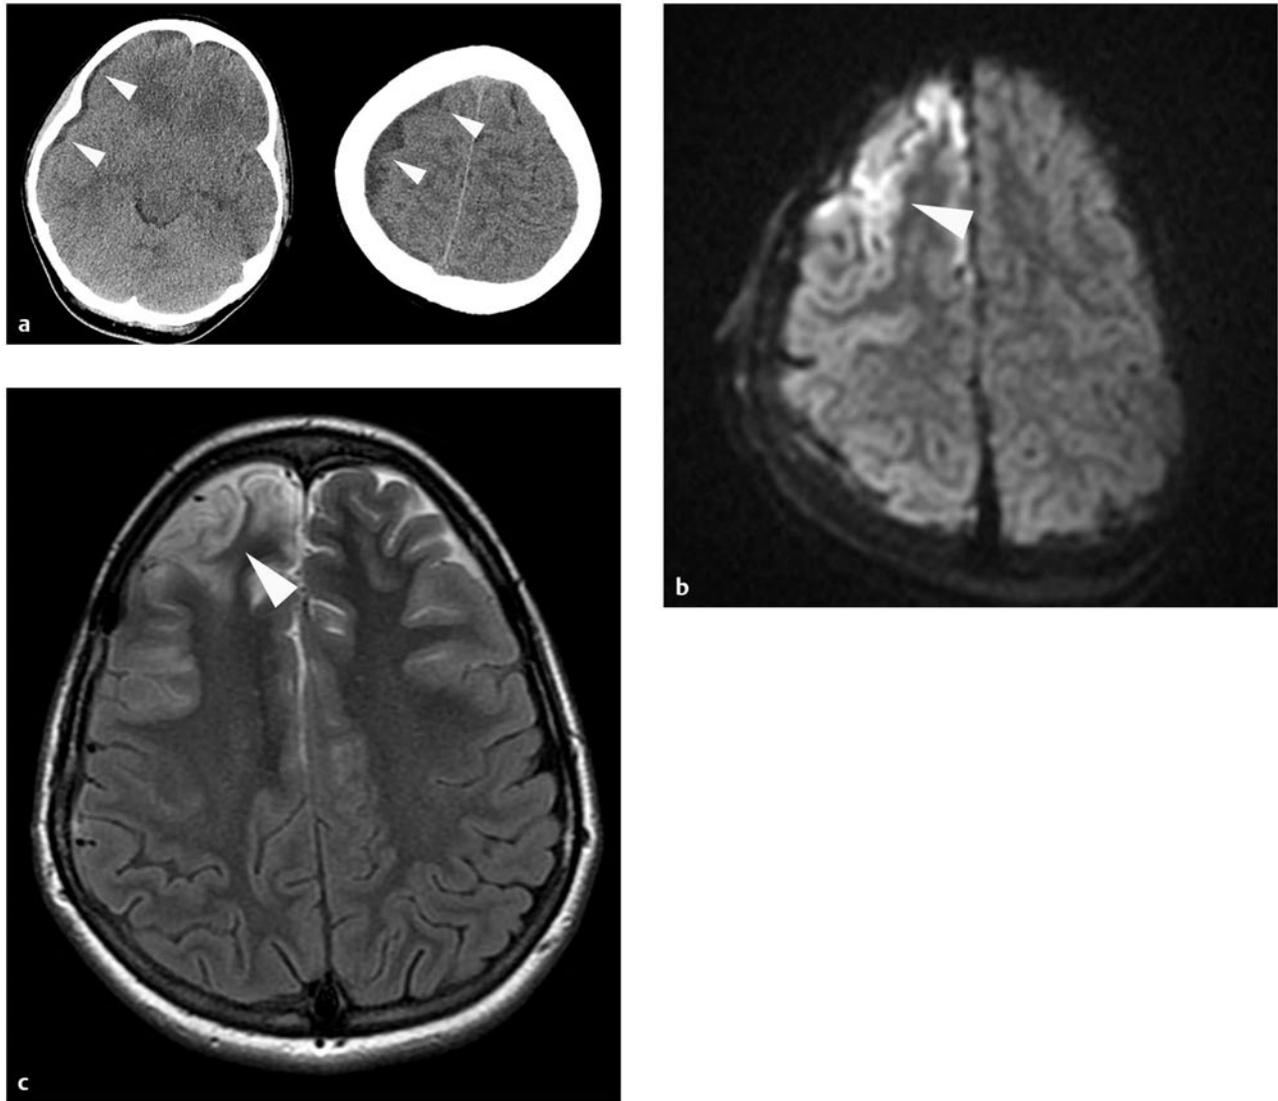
(a) This school-age girl collapsed at home after several days of headaches and fevers. In the emergency department, she was noted to be hemiplegic on the left side. A computed tomographic scan of the head without contrast shows a thin, low-density subdural collection (white arrowheads) distributed widely over the right convexity. She underwent immediate osteoplastic right frontoparietotemporal craniotomy for drainage of her empyema. Her postoperative course was notable for septic shock requiring aggressive fluid resuscitation and pressors. (b) The diffusion-weighted image (DWI) from a study performed on the third hospital day shows high signal intensity in the cortical mantle of the right frontal lobe (*white arrowhead*). (c) At late follow-up, her hemiplegia had resolved completely, but she has persisting neurocognitive disabilities and is continuing in rehabilitation. This T2-weighted axial MR imaging sequence shows encephalomalacia (*white arrowhead*) at the site of the abnormality on the earlier DWI sequence.
